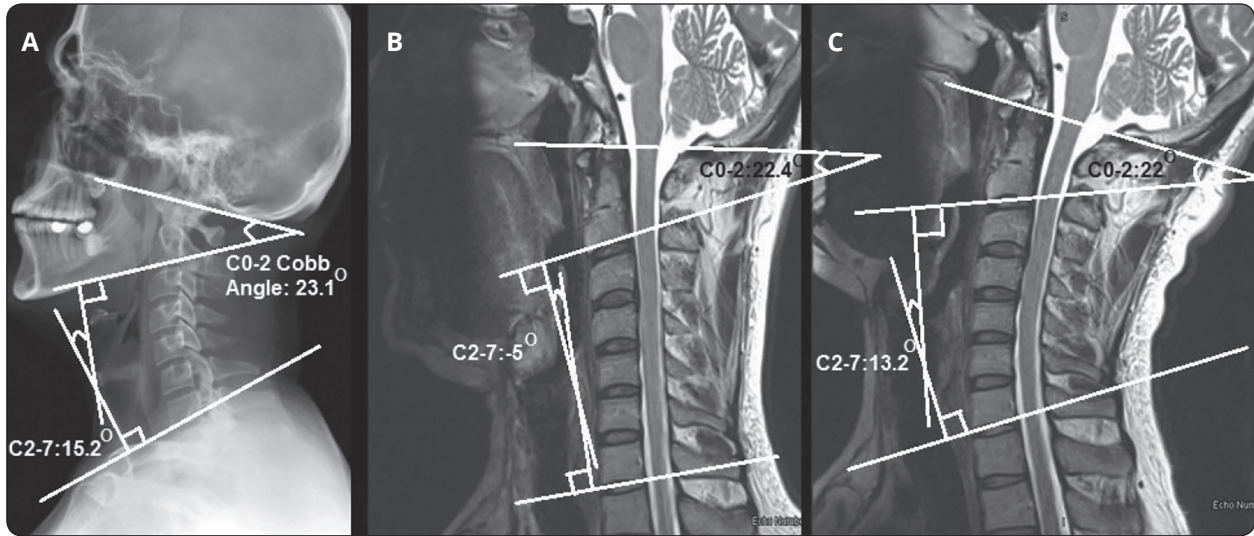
X-ray (A), Neutral MRI (B) and extending MRI (C)
